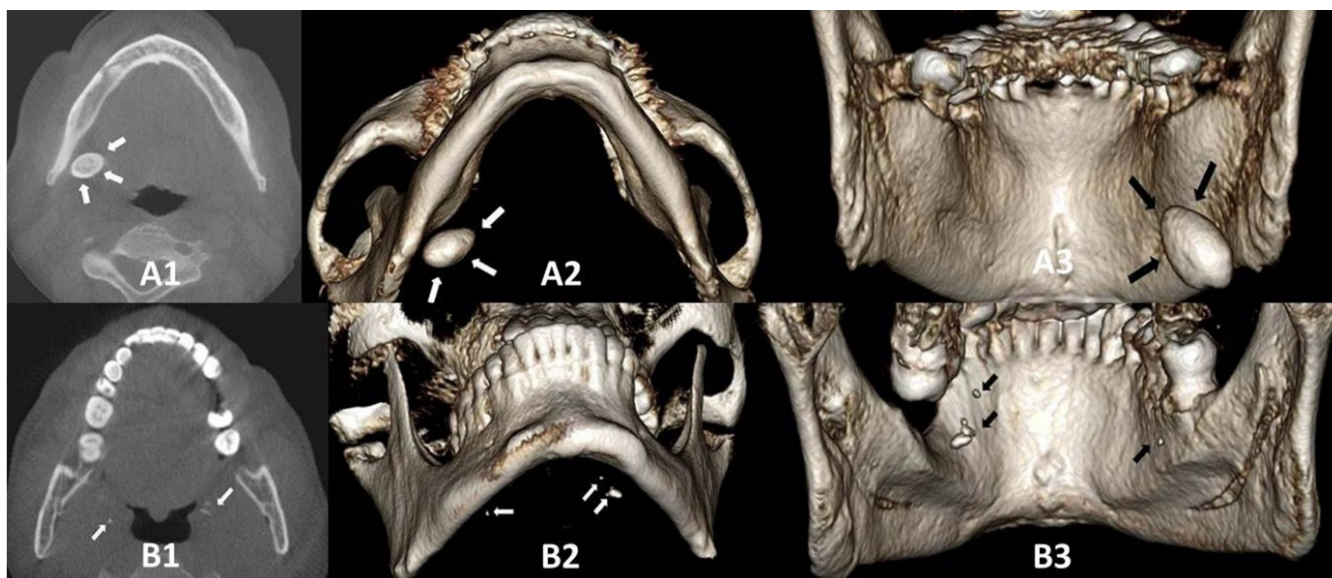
STC samples are shown with arrows: A1, B1 (coronal CBCT image); A2, B2 (base of mandible's 3D reconstructed image); A3, B3 (inside of the mandible's 3D reconstructed image)
